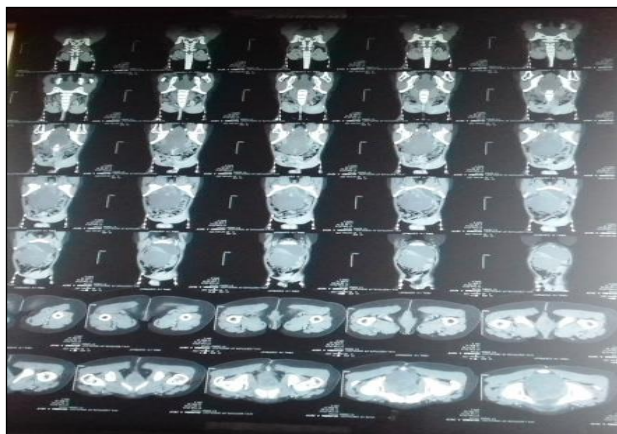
CT image showing mass in retroperitoneum.
